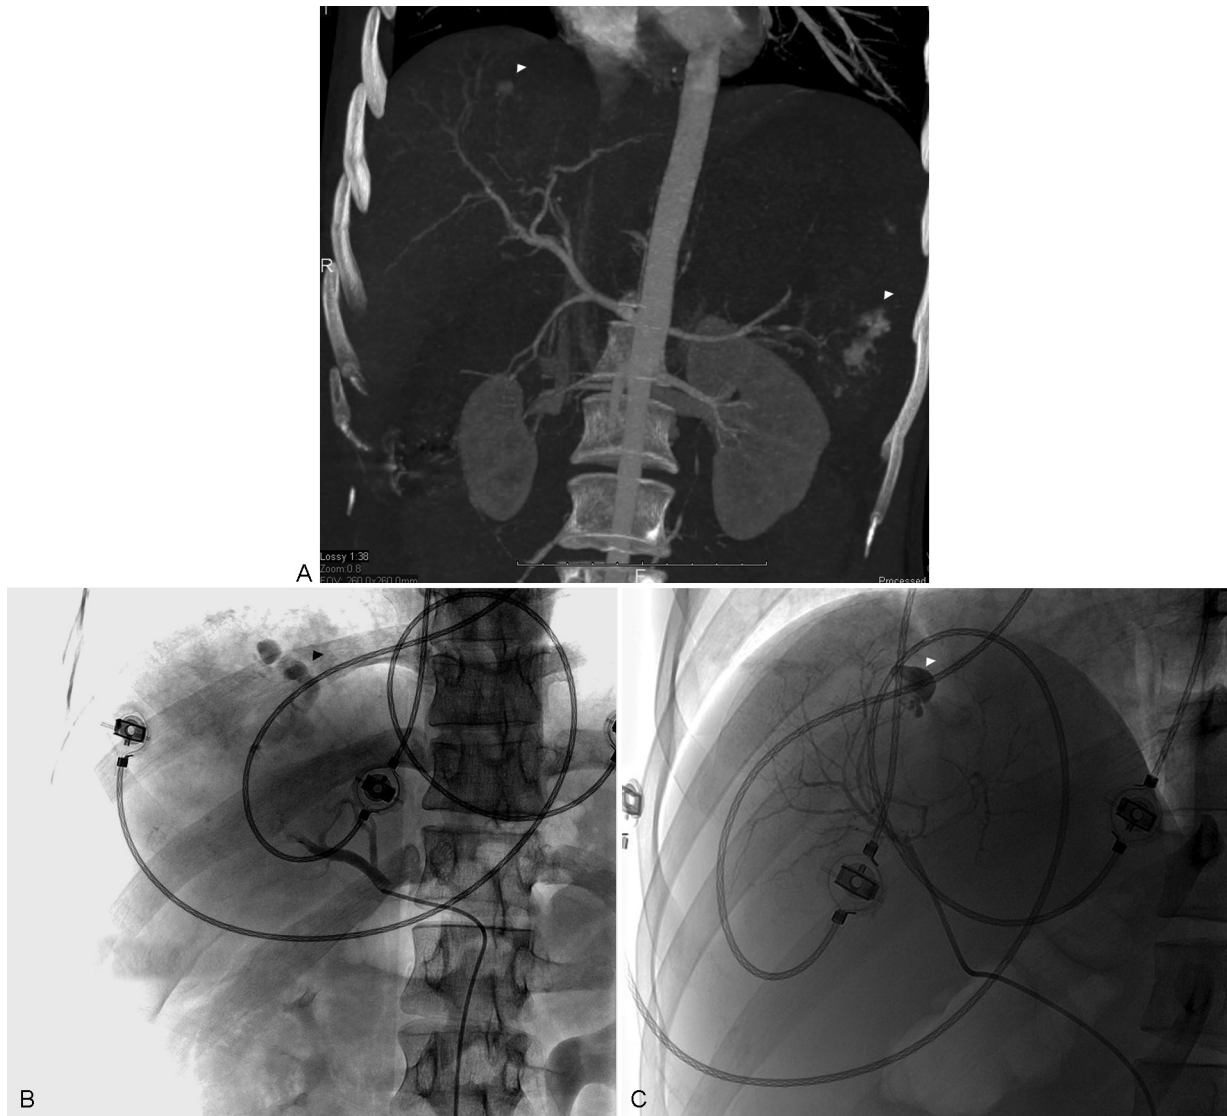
(A) Computed tomography shows active extravasation from the liver and spleen. (B) Hepatic angiography shows active extravasation of contrast material from segment 8. (C) Postembolization angiography shows no further bleeding.
